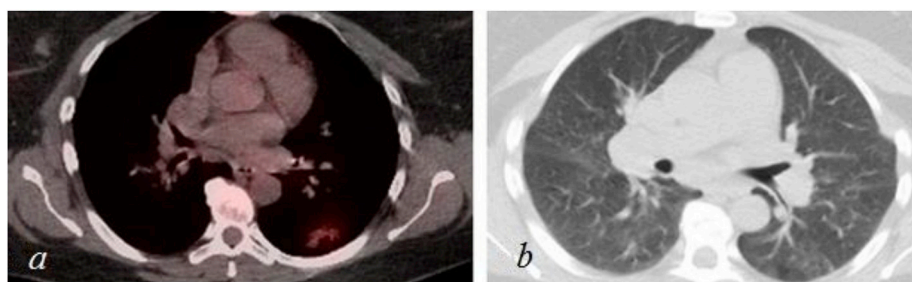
5a,5b: Post treatment positron emission tomography/computed tomography and chest computed tomography showing resolution of the left lower-lobe mass.
